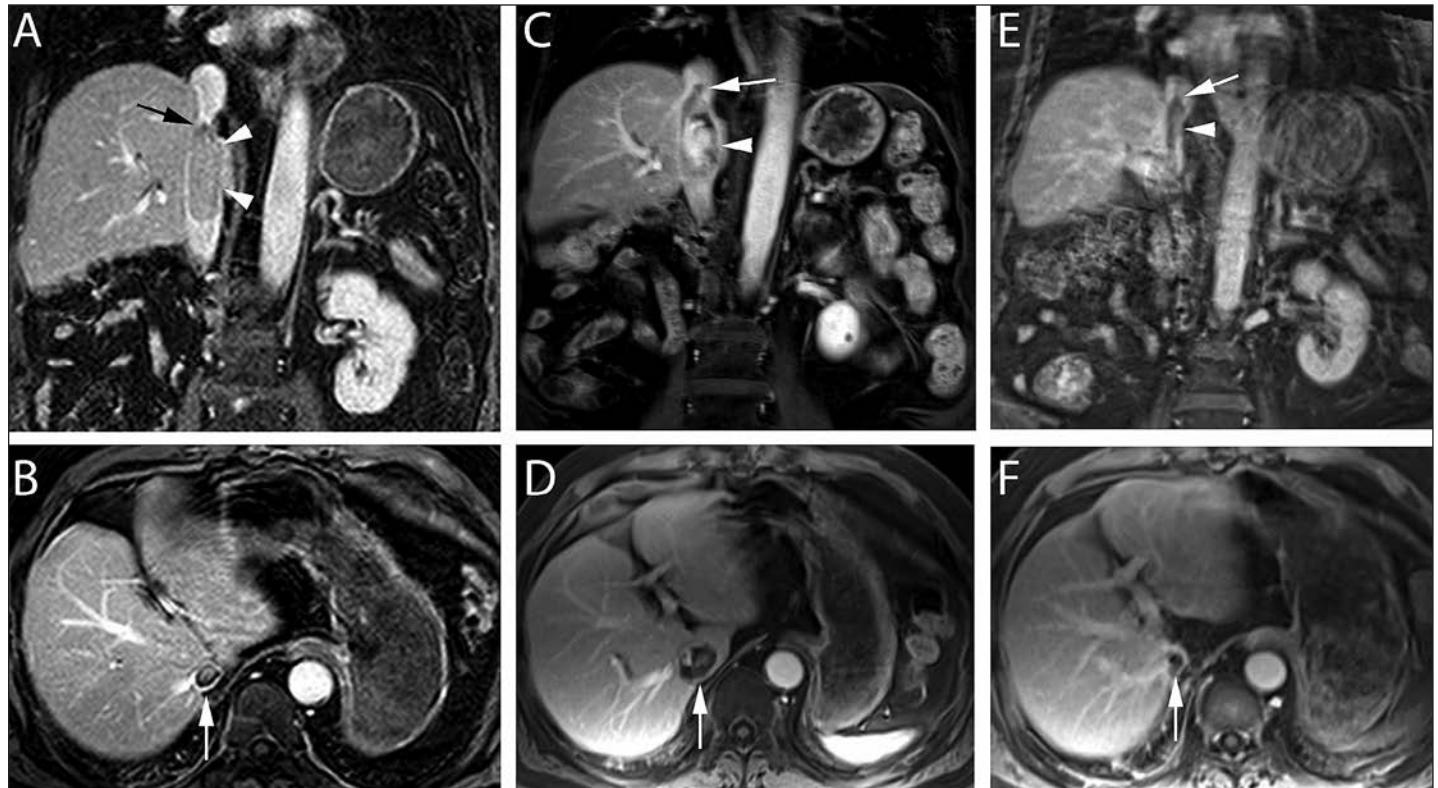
MRI of IVC Tumor Thrombus in clear cell RCC before and after SAbR. Coronal (top) and axial (bottom) contrast enhanced MR images at different time points during the course of treatment. After nephrectomy and thrombectomy, the patient had an intraluminal recurrence of tumor thrombus, which was adherent to the IVC wall (arrowheads, A). The superior extent of the thrombus is inferior to the diaphragm (Level III; arrow, A). Note the size of the thrombus at the level of the right hepatic vein (arrow, B). After systemic
